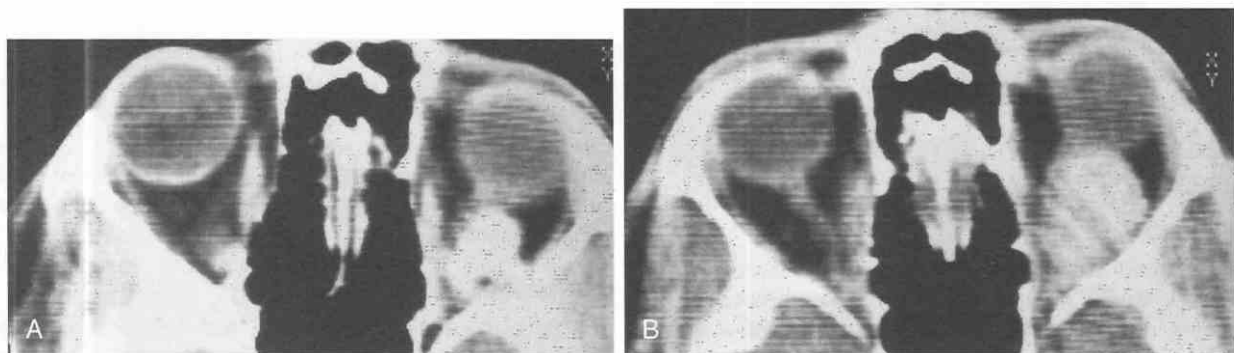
Axial contrast-enhanced CT scan. Orbital varix both before (*A*) and during (*B*) Valsalva's maneuver demonstrates the increase in size of the lesion. (Courtesy of Robert E. Peyster, M.D., Hahnemann Hospital, Philadelphia.)
